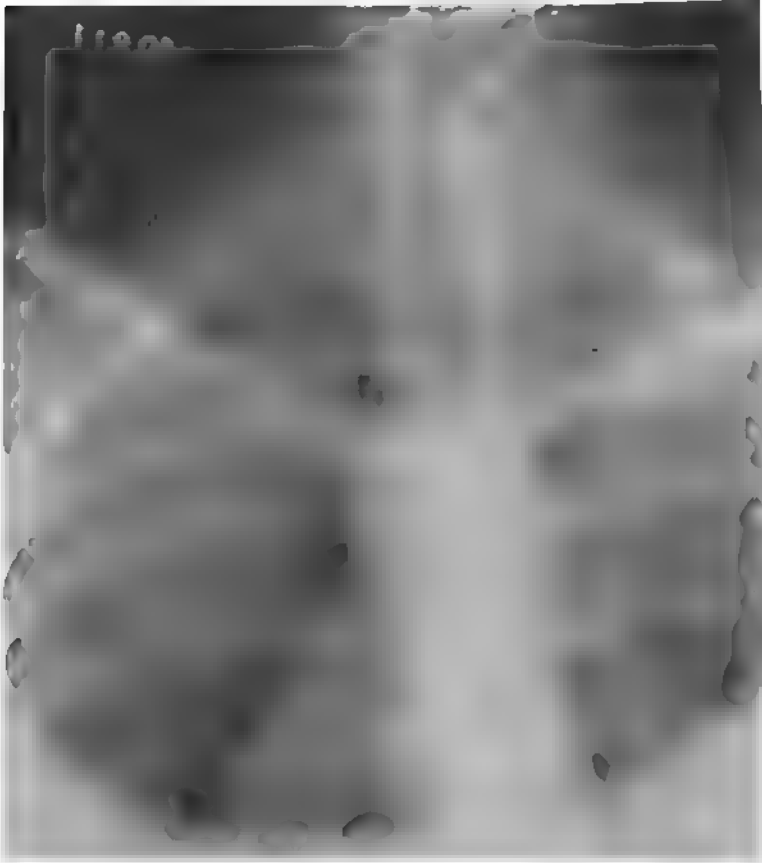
Case No. A45570. X-ray 10217. Mrs. J. L., aged twenty-seven. Physical examination showed fulness and tumor in left supraclavicular fossa. X-ray showed well-marked left seventh cervical rib rudimentary on the left; no definite symptoms. Operated on for double tuberculous salpingitis.
